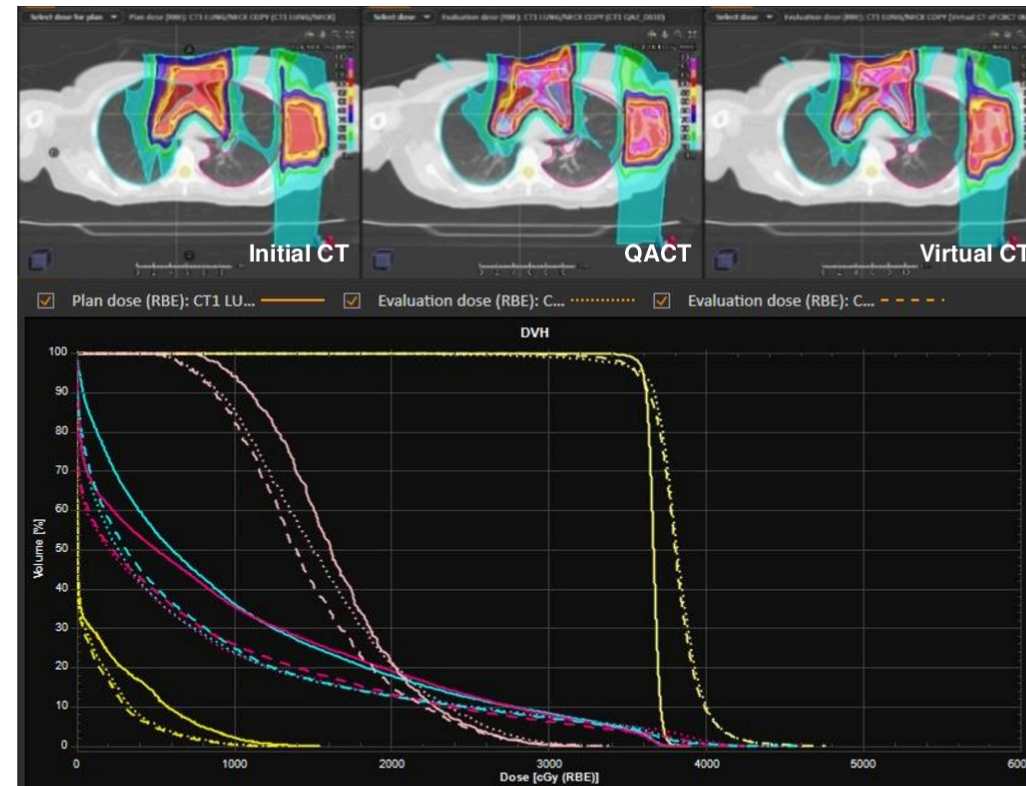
Dose distribution and dose volume histograms of a lung case that required ART. High agreement between the virtual-CT and reference QA-CT were observed. Solid line (planning CT), dotted line (QA-CT), dashed line (CBCT-based Virtual CT).
